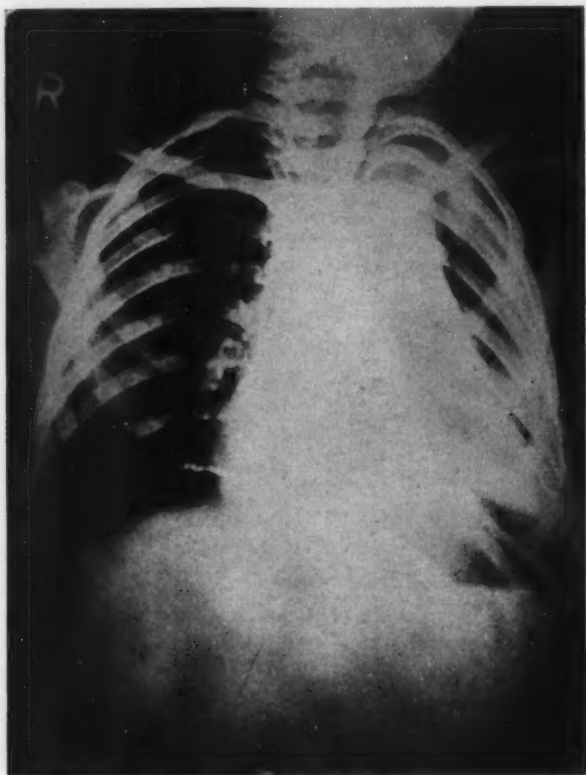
X-ray following surgical drainage and the incident when the drainage tube was found out of the water. This revealed a left pneumothorax.
